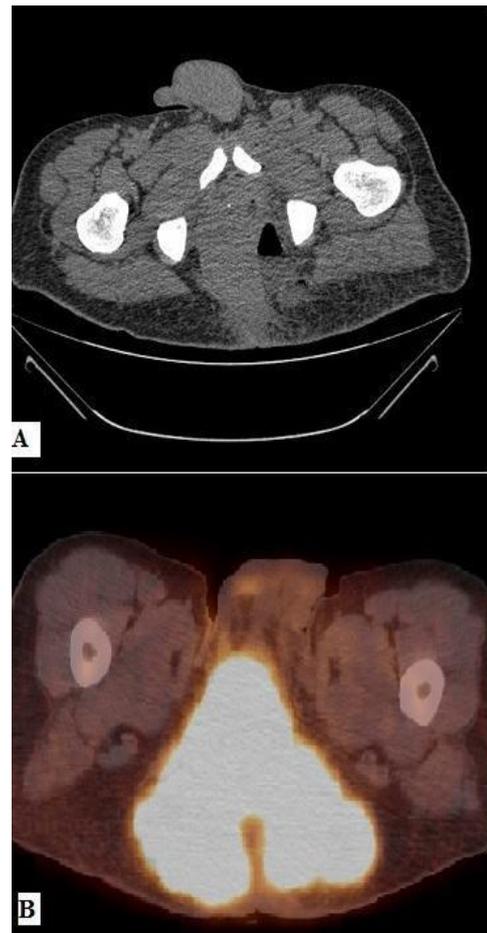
A-CT Pelvis with contrast showing perianal mass. B- PET CT of Primary anal tumor
